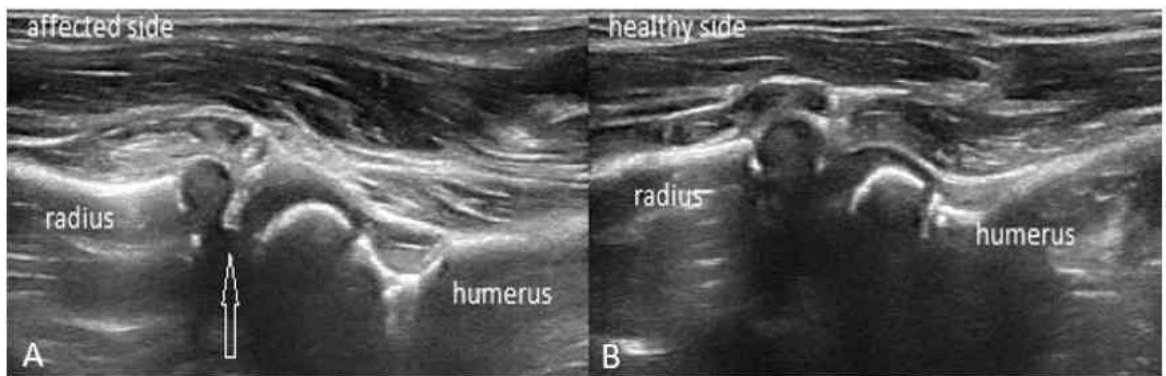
Ventral views of the sonographic two-point examination of pulled elbow. Synovial fringe enlargement.
